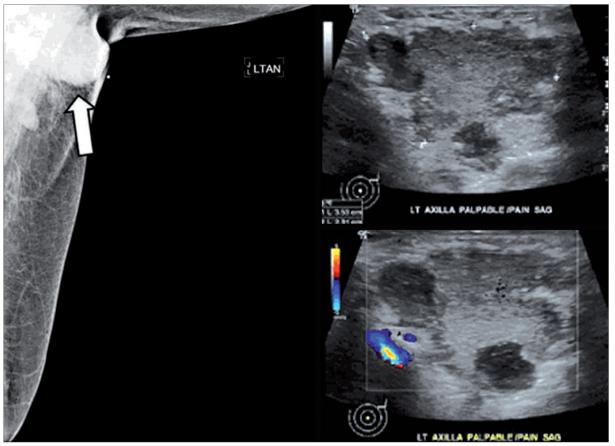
A 53-year-old female patient with a tender left axillary lump. On the spot tangential view of the left axilla (BB marker is over palpable lesion), there is a dense, ill-defined mass, and surrounding enlarged axillary lymph nodes are easily seen (*arrow*). The sagittal US image shows a complex mass with adjacent hypoechoic nodules that have the appearance of enlarged lymph nodes lacking a normal fatty hilum. Color Doppler US demonstrates no flow within it. The diagnosis was abscess formation secondary to bacterial lymphadenitis.
